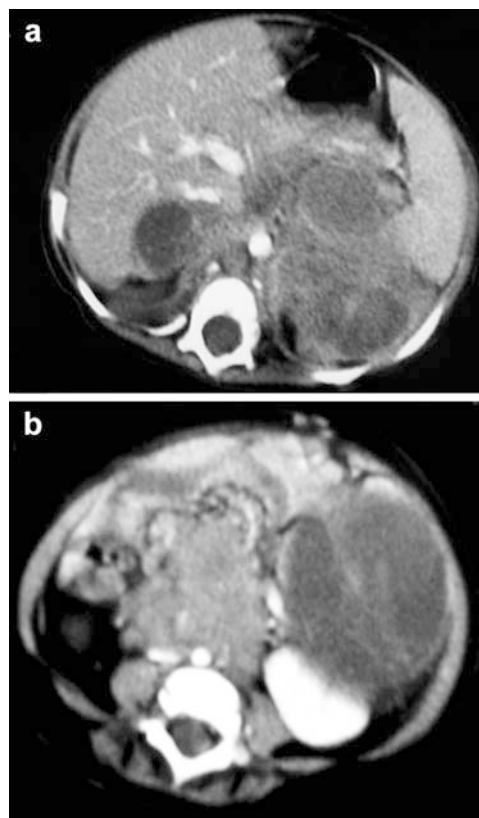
Contrast-enhanced CT a at the level of the adrenals showing bilateral cystic adrenal masses and b more caudally, showing lymphadenopathy surrounding the aorta and a large cystic mass displacing the left kidney
